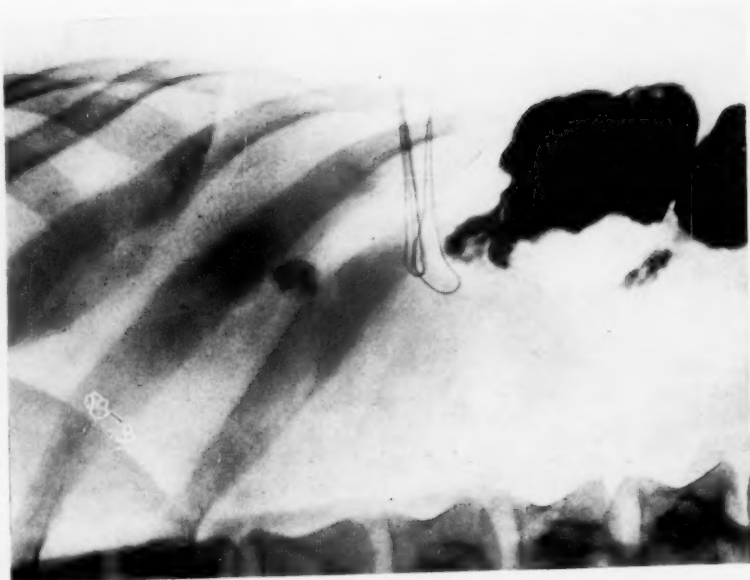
Roentgenogram of the right upper quadrant of an obese female. The "fiberglass" thread is contrasted with residual barium in the large bowel and a gallstone.
